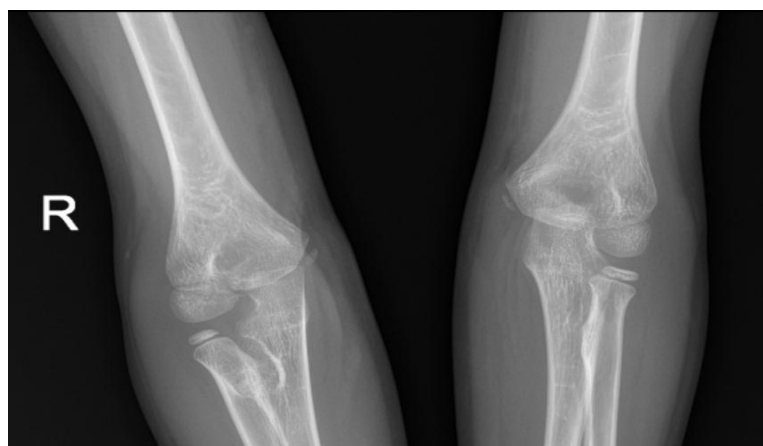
X ray (AP Radiograph) shows sclerosis in the proximal parts of radius and ulna and the margins of proximal ulna and radius cannot be differentiated in the region. Left elbow radiograph appears normal.
